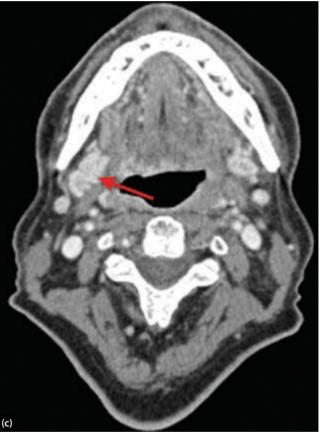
Salivary gland changes after radiotherapy. (a) PET-CT demonstrates left base of tongue tumour; (b) Enhanced CT (sagittal) shows avidly enhancing SMG; (c) Enhanced CT (axial) shows avidly enhancing SMG; (d) US demonstrates hypoechoic, hypervascular gland.
